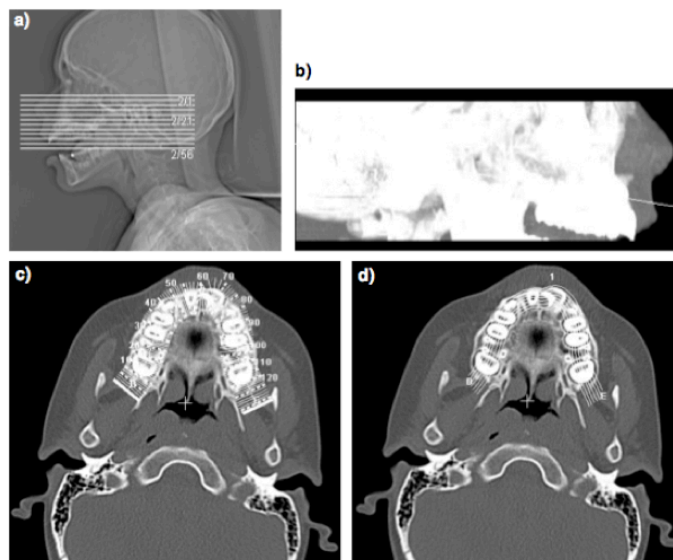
Images obtained in CT exam and Dental CT evaluation. a) Patient's head topogram showing ROI selected (upper jaw); b) Lateral MIP (Maximum Intensity Projection) view of the maxilla. This image has an orientation line in order to choose an image with the best plane (transaxial or oblique) to define reformatted final images; c) Transversal and d) Parallels lines overlapped on the arch of the maxilla in order to generate the cross-sectional and panoramic images, respectively.
